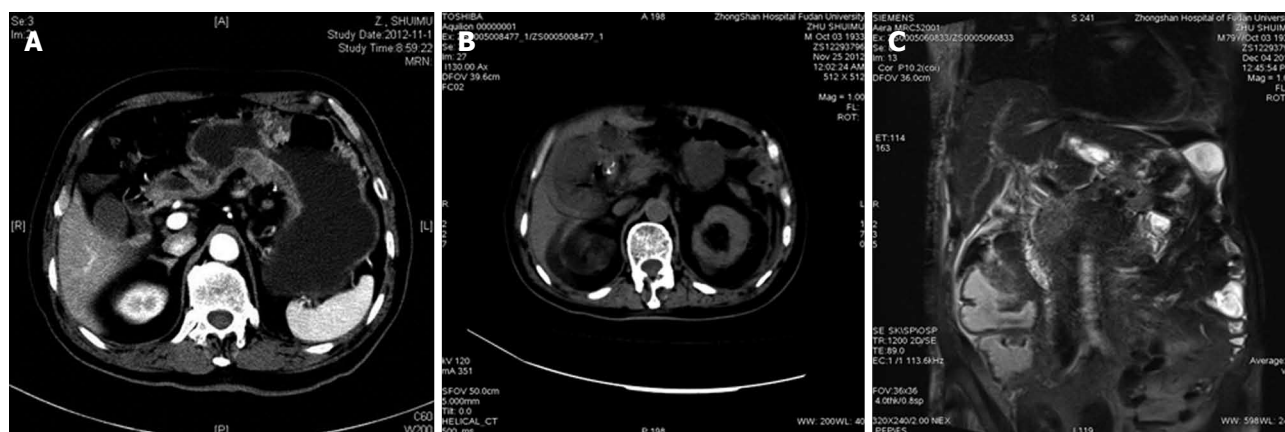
Computed tomography scan in case 2 displaying normal gallbladder (A) before operation, thickened gallbladder wall and swelling gallbladder (B), and magnetic resonance imaging showing no dilation of bile ducts on the 19th day after operation (C).
